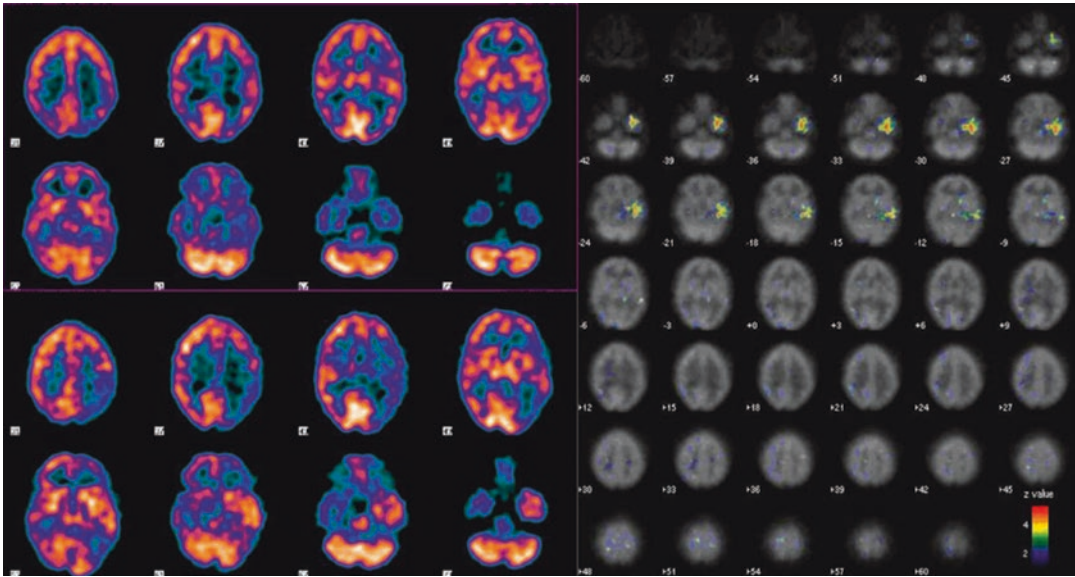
(Left) An interictal ^{99m}Tc -ECD brain SPECT scan (top) as compared with an ictal ^{99m}Tc -ECD brain SPECT scan (bottom). On the ictal brain SPECT scan, one can see increased hyperemia involving the left temporal lobe. (Right) Using SPM statistical comparison, one can
